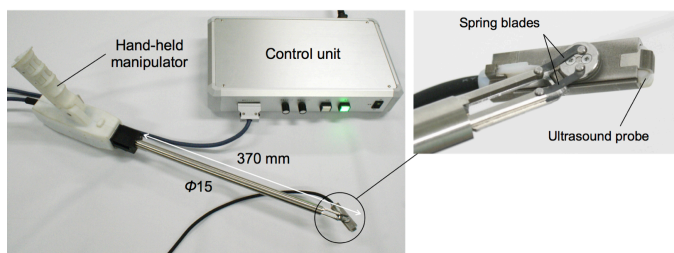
The prototype consists of a handheld laparoscopic ultrasound manipulator and an ultrasound control box. A commercialized laparoscopic ultrasound probe (L43K; Hitachi Medical) can be attached to the tip of the manipulator.
